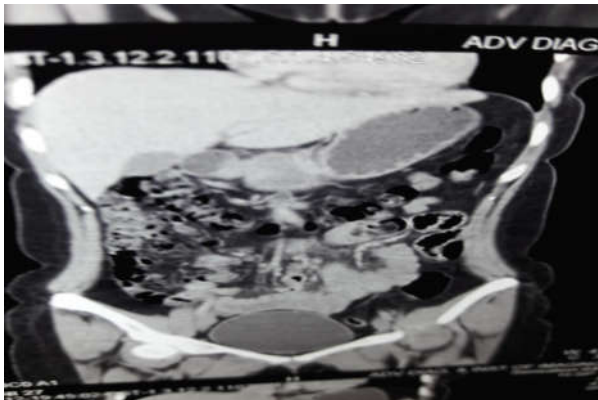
Showing CT Abdomen Showing Intussusception
